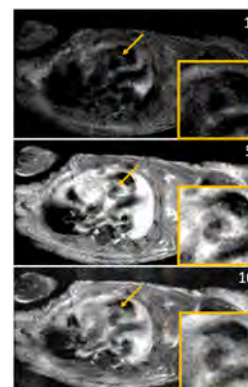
Compressed sensing reconstruction of self-gated DCE-MRI of the aortic root. Orange arrow and zoomed-in inserts, aortic root. Numbers indicate temporal frames. The same cardiac phase was depicted.
